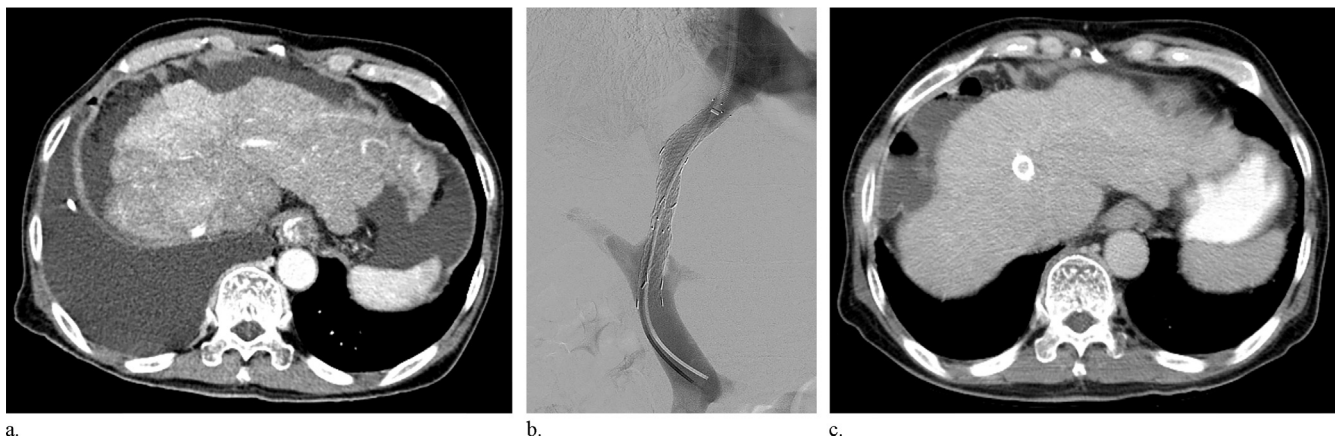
(a) Contrast-enhanced CT image of the chest and abdomen obtained on hospital admission shows a large, right-sided pleural effusion. (b) Portogram obtained immediately after TIPS creation shows good passage of contrast medium through the shunt. (c) Contrast-enhanced CT image of the chest and abdomen obtained 2 years and 10 months after TIPS creation shows no recurrence of pleural effusion.
